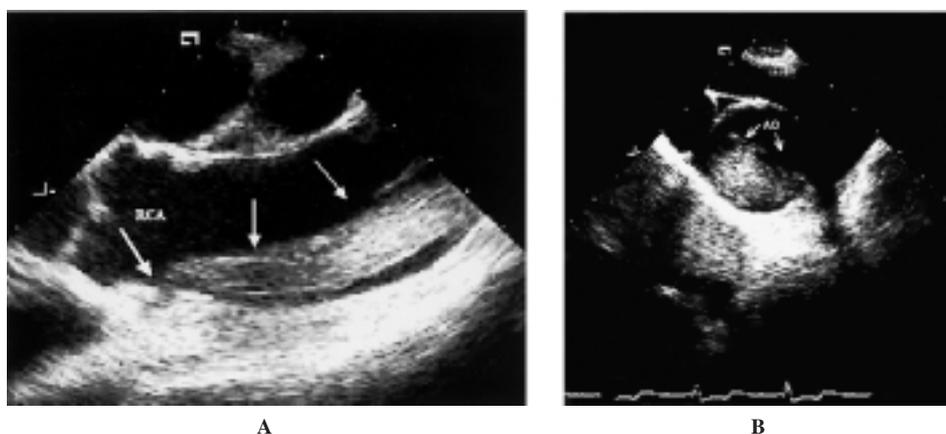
Transesophageal echocardiographic study following the coronary intervention procedure. A: long axis of the ascending aorta (AO); B: short axis of the ascending AO. An echogenic image on the anterior wall starting from the ostium of the right coronary artery (RCA) may be clearly seen.
